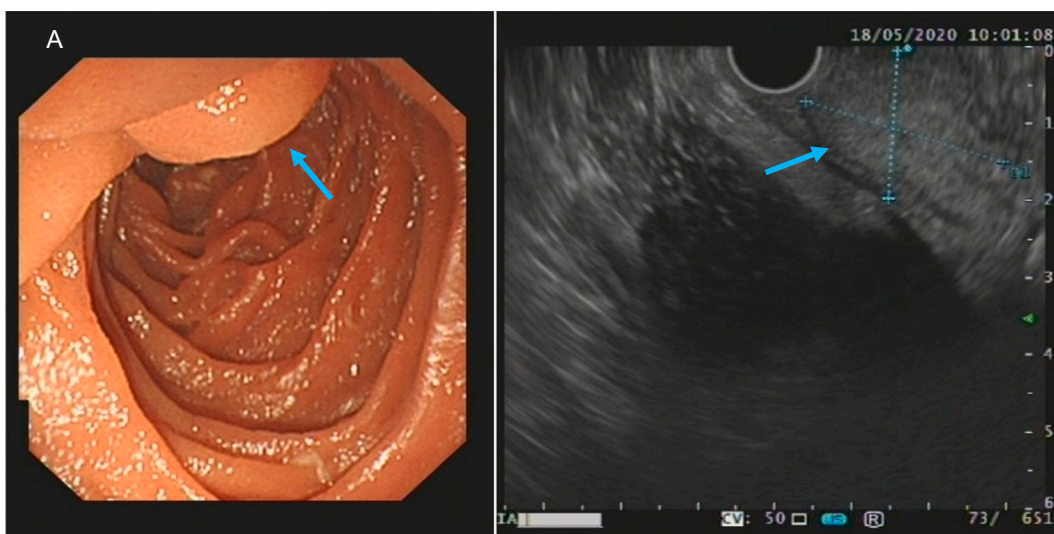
(a) Endoscopic Retrograde Cholangiopancreatography showing a 3 × 4 cm mass at the location of the major duodenal papilla. (b) A 2.2 × 1.7 cm nodule identified on Endoscopic Ultrasound in the head of the pancreas.
